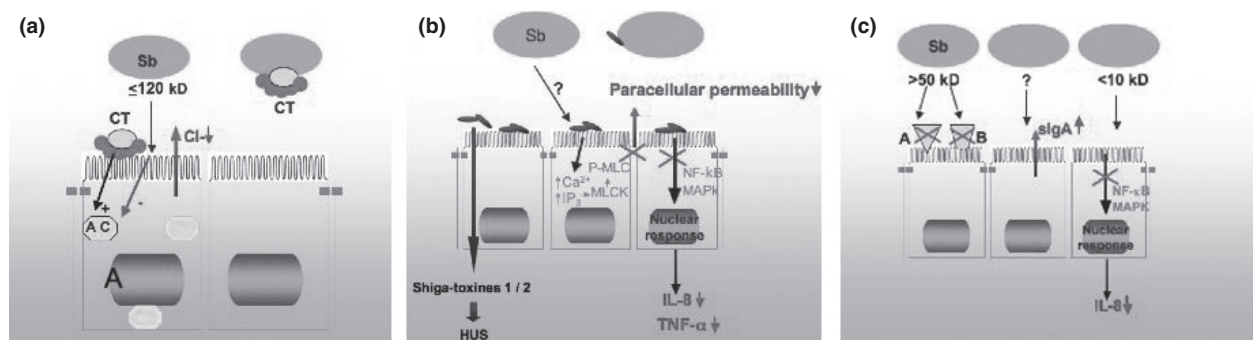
Proposed model for the mechanism of action of *Saccharomyces boulardii* against *Vibrio cholerae* (a), *Clostridium difficile* (b) and pathogenic *Escherichia coli* (EPEC and EHEC) infections (c). (Panel a) *Saccharomyces boulardii* produces a 120 kDa protein that exerts an effect on intestinal mucosa and inhibits cholera toxin (CT)-stimulated adenylate cyclase (AC) and chloride secretion. *Saccharomyces boulardii* also binds CT. (Panel b) *Saccharomyces boulardii* acts on intestinal mucosa and decreases phosphorylation of MLC implicated in the control of tight junctions as well as activation of MAPK and NF-κB implicated in the synthesis of proinflammatory cytokine IL-8 and TNF-α. (Panel c) *Saccharomyces boulardii* secretes a protease (>50 kDa) that lyses *C. difficile* toxins A and B and a protein (<10 kDa) that inhibits the signalling pathway implicated in IL-8 synthesis. *Saccharomyces boulardii* stimulates antitoxin A IgA production.
